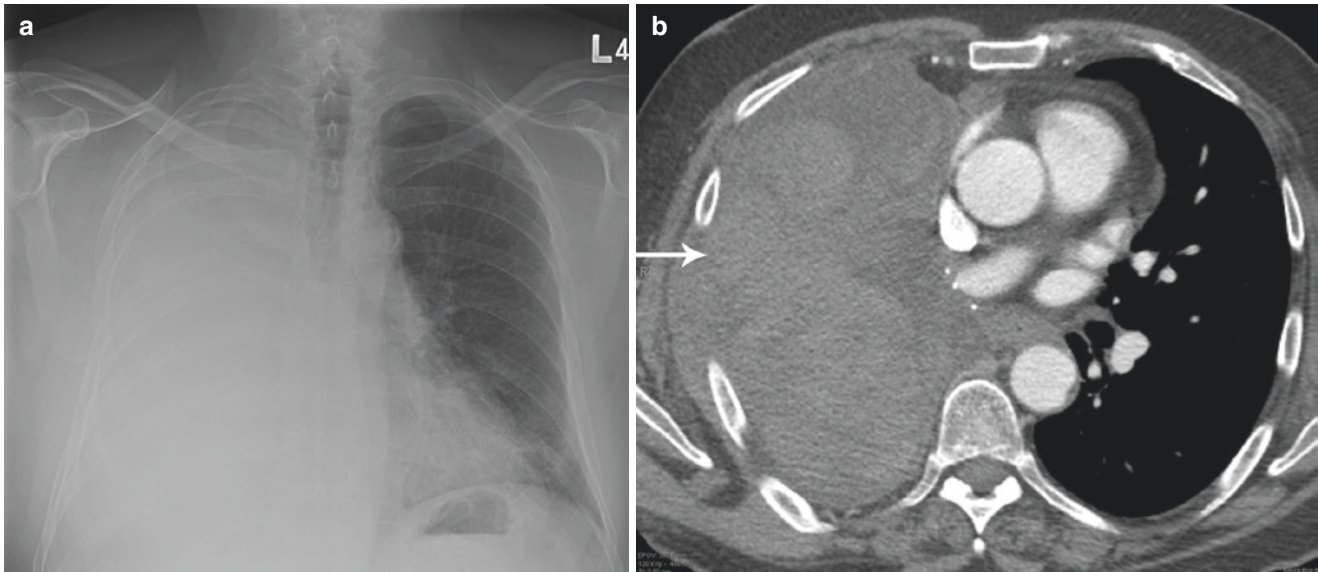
(a) Frontal chest radiograph shows complete opacification of the right hemithorax; (b) contrast-enhanced axial CT shows heterogeneous attenuation in the right pleural fluid in the pneumonectomy space consistent with blood products (arrow)
